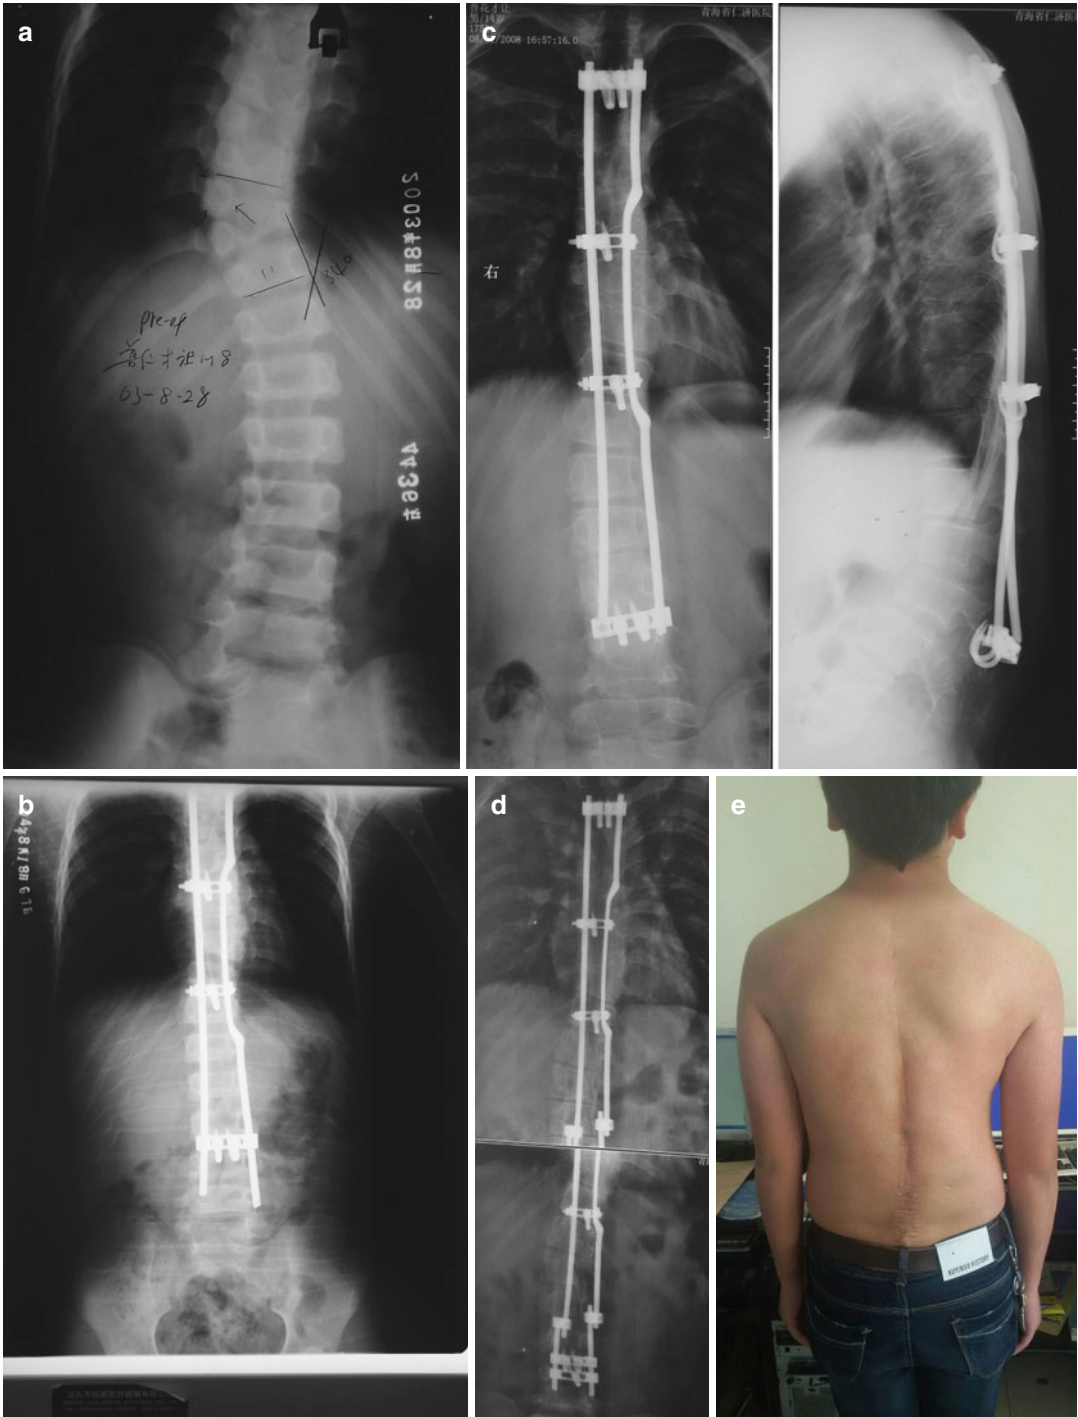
PRCY M 9, hemivertebral scoliosis: preop 34° (a), post-op 0° (b). Another radiograph taken 5 years later shows curve correction maintained, the lower end of rods sliding out of the lower connector (c), which was elongated with tandem connector (d). Good posture was seen (e)
